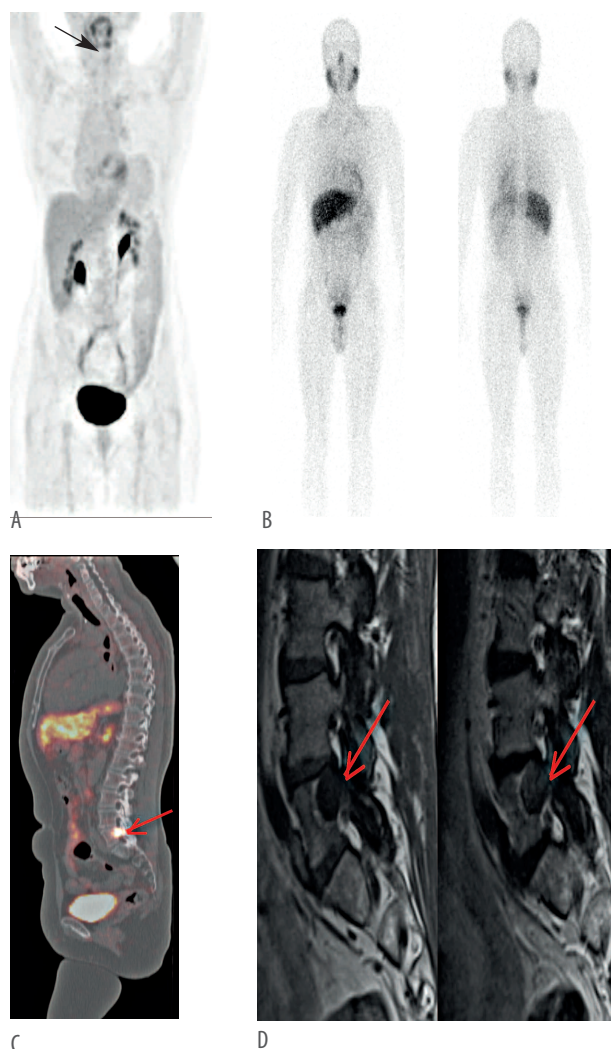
Recurrent MTC presenting with small right cervical nodes. ^{18}F -FDG PET/CT MIP showing low-level metabolic activity in cervical nodes (arrow) (A). ^{123}I -MIBG scan was negative (B). ^{68}Ga -Dotatate PET/CT fused sagittal view showed intense uptake in the left L5 pedicle (C). An MRI of the lumbar spine (D) was performed demonstrating a lesion in the left L5 pedicle (red arrows) and a bone biopsy showed recurrent metastatic MTC.
